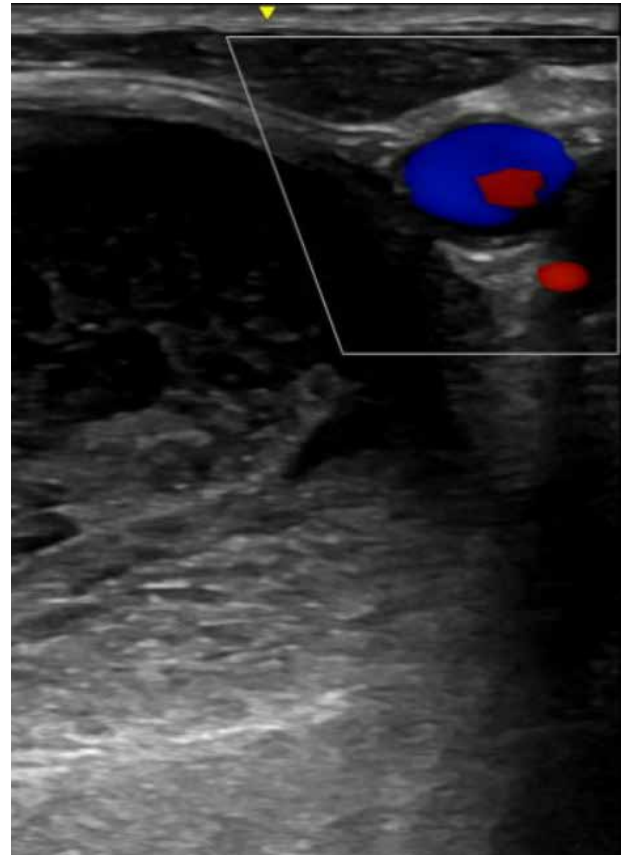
Ultrasound findings
